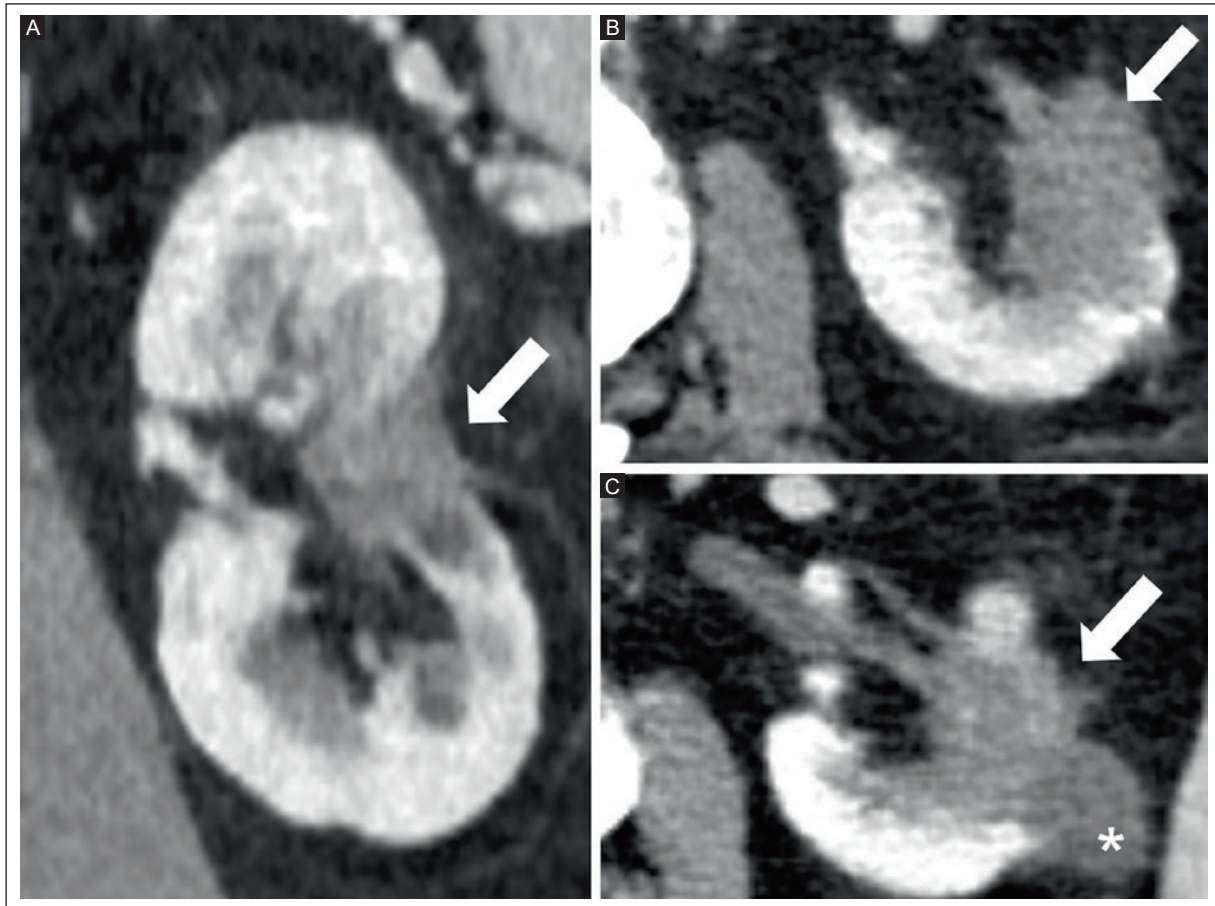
CT of a 78-year-old man diagnosed with metastatic UCC to the bone. A: coronal and B: axial planes show an infiltrative lesion with an ill-defined border, invading the renal cortex, medulla, renal sinus and calyces on nephrographic phase CT (arrows). C: the lesion (arrow) is associated with an adjacent cystic lesion (asterisk).
